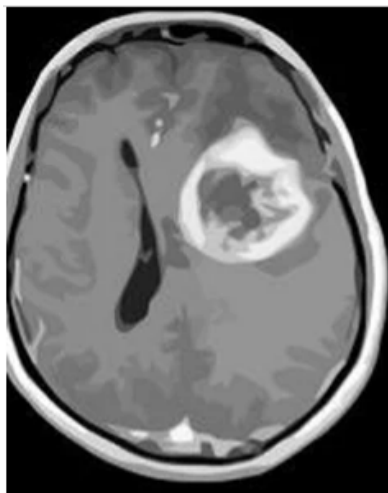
Axial T1-weighted MRI with gadolinium enhancement showing a left frontal glioblastoma.
